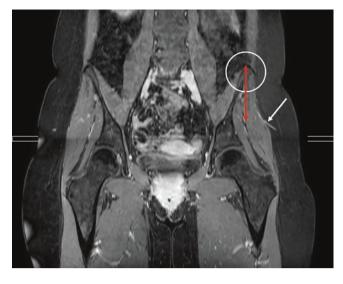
Example of T1-weighted, fat-suppressed THRIVE sequence of the pelvis, reconstructed in the coronal plane. Based on the findings of previous figures, the exit of the perforator through the gluteal muscles can be identified (white arrow), as well as the iliac crest (circle). Next, the distance from the iliac crest to the expected exit of the perforator can be estimated, in this case 8 cm (red arrow)
